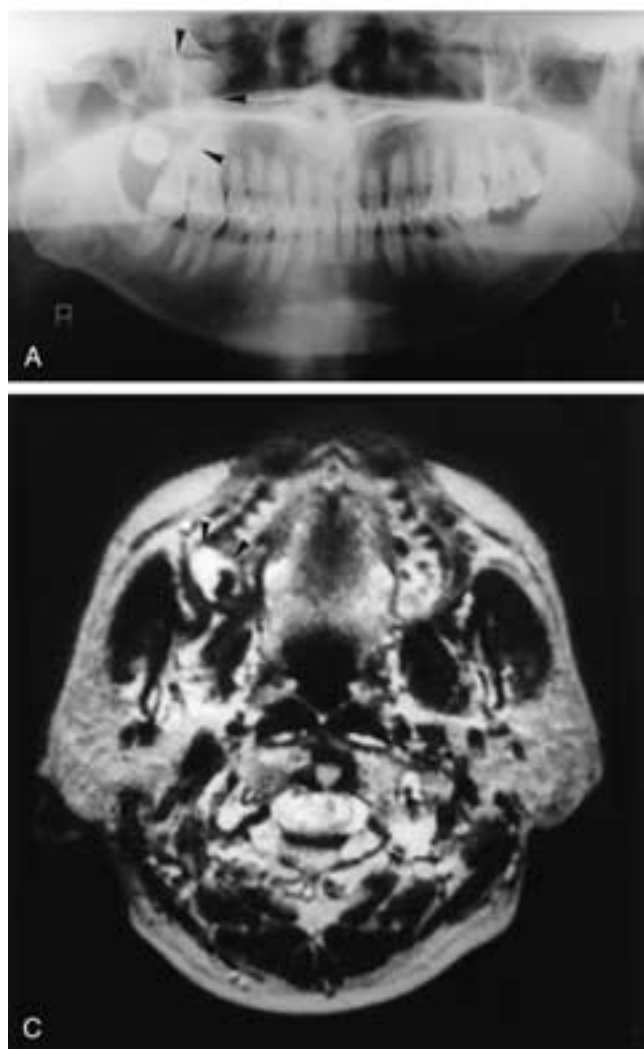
Dentigerous cyst. A, Pantomogram shows a well-defined lesion with an unerupted tooth involving the right maxillary sinus (*arrowheads*). Dentigerous cyst is strongly suspected, but unilocular ameloblastoma and OKC cannot be ruled out. B, Axial T1-weighted image reveals an unerupted tooth as signal void (*arrowheads*) within a low-intensity lesion. C, Axial T2-weighted MR image reveals a pericoronal lesion of homogeneously high intensity (*arrowheads*). MR findings suggest a pericoronal cyst containing homogeneous fluids and an unerupted tooth, most likely a dentigerous cyst.
